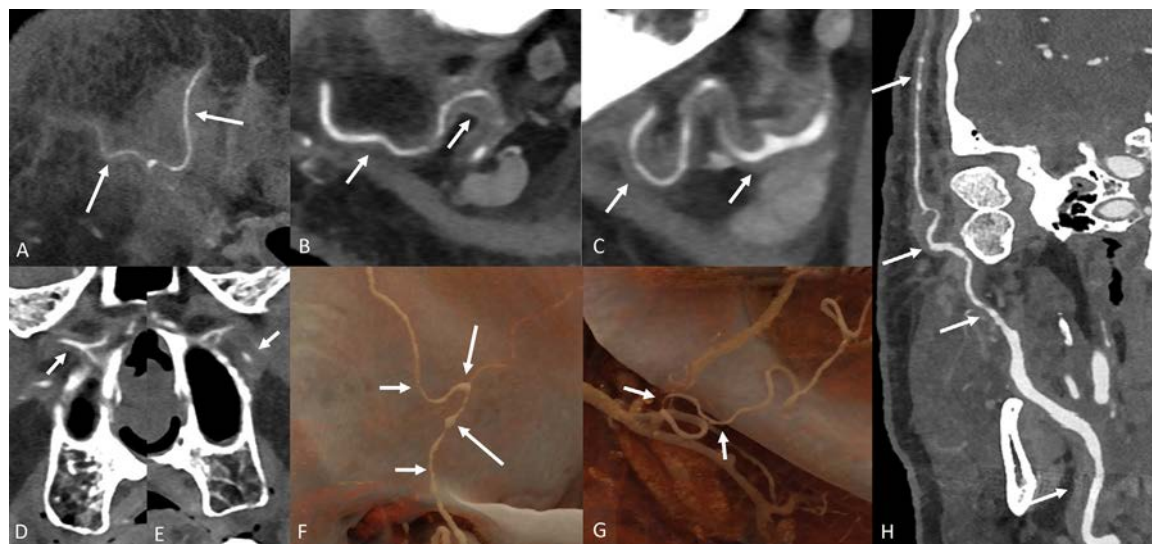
Sagittal (A–C) and coronal (D–E) multiplanar reformats from photon-counting CT angiogram source images show wall thickening and fat stranding (arrows) involving the right superficial temporal (A), bilateral facial (B, C), and maxillary arteries (D, E). Volume rendered images (F, G) show areas of luminal narrowing (short arrows) and pseudoaneurysms (long arrows) along the right STA (F) and right facial artery (G). Curved MPR (H) shows extensive involvement along the right ECA extending till the frontal branch of right STA (arrows). ECA, external carotid artery; MPR, multiplanar reconstruction; STA, superficial temporal artery.
